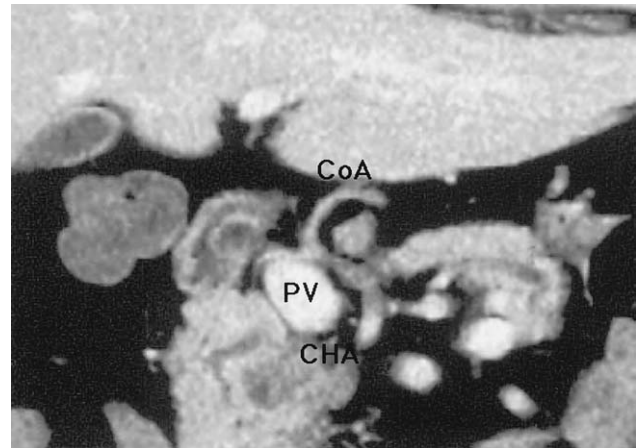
Coronal image processed by multislice computed tomography showing the common hepatic artery, which runs ventrally to the portal vein and gives rise to the collateral artery. CHA = common hepatic artery; CoA = collateral artery; PV = portal vein.
